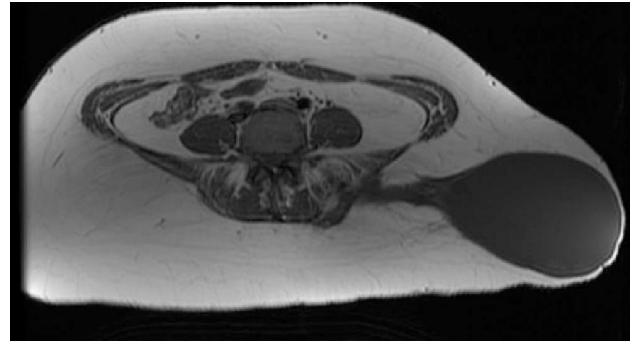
(a): MRI, axial sections, T1WI showing well defined hypointense collection in the subcutaneous tissues of left gluteal region.
